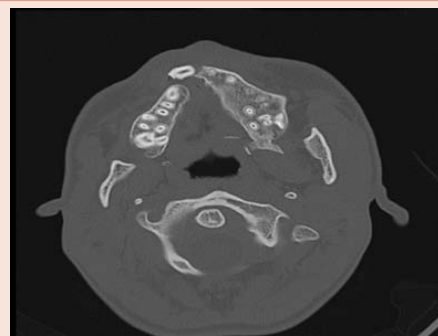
CT-axial imagine shows cleft lip and cleft palate.
